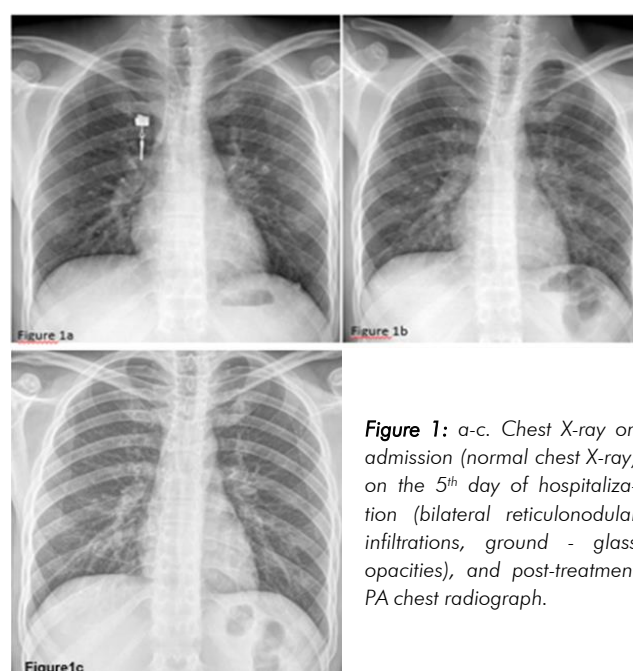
a-c. Chest X-ray on admission (normal chest X-ray), on the 5th day of hospitalization (bilateral reticulonodular infiltrations, ground - glass opacities), and post-treatment PA chest radiograph.
